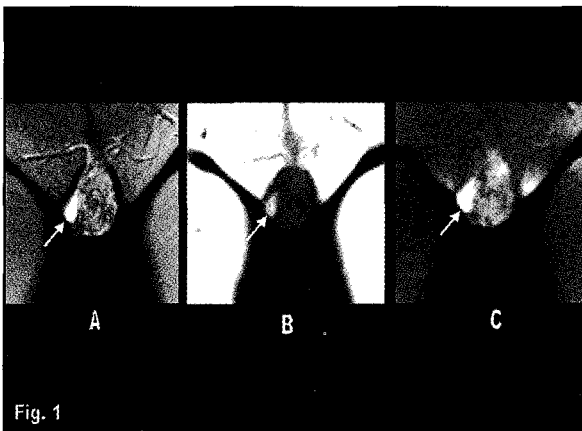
A - T2 fat saturation coronal MRI. B - T1 image showing lesion isointense to muscle. The area indicated by arrow remains hyperintense, indicating the presence of blood products from a subacute hematoma. C-T1-fat saturation image following gadolinium.
